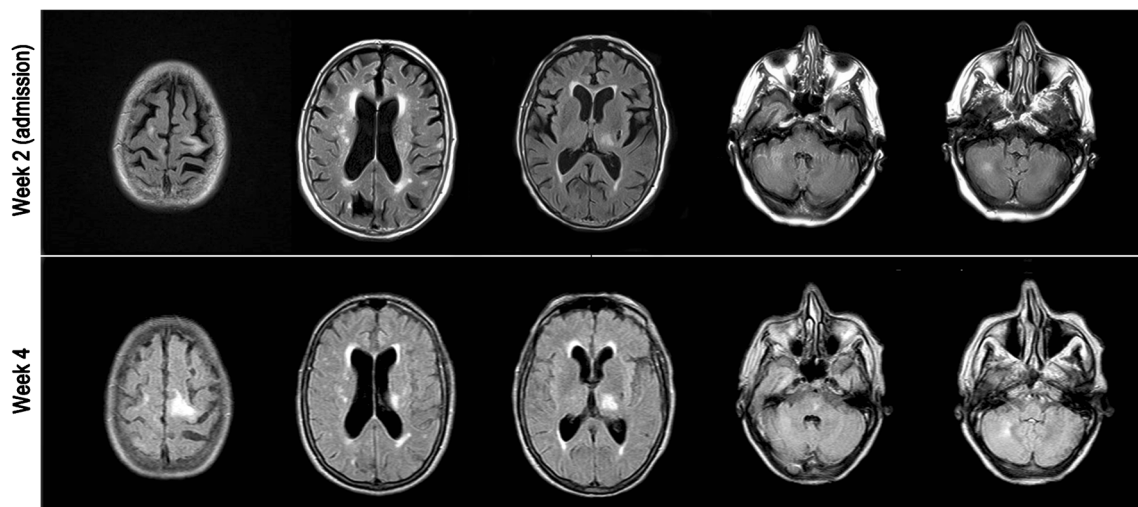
Brain MRI at diagnosis and at follow-up
